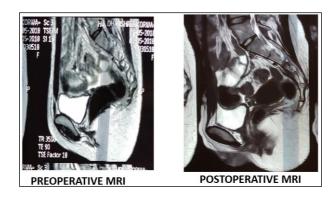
Pre- and post-operative MRI findings.
